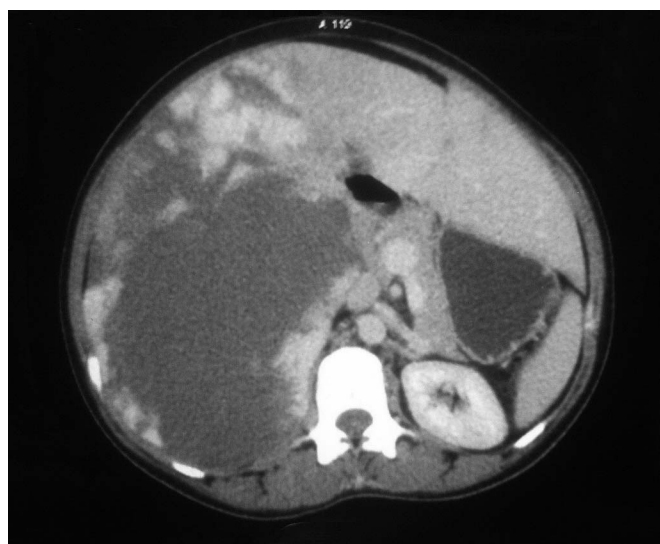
Multidetector computed tomography axial section showing giant hemangioma replacing the right hemiliver and caudate lobe.
